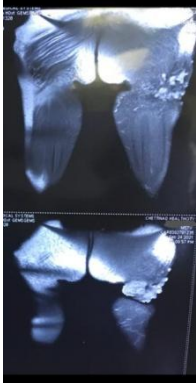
MRI image of left thigh showing invasive lesion in gluteal region involving cutaneous, subcutaneous fat and underlying muscle layer.
